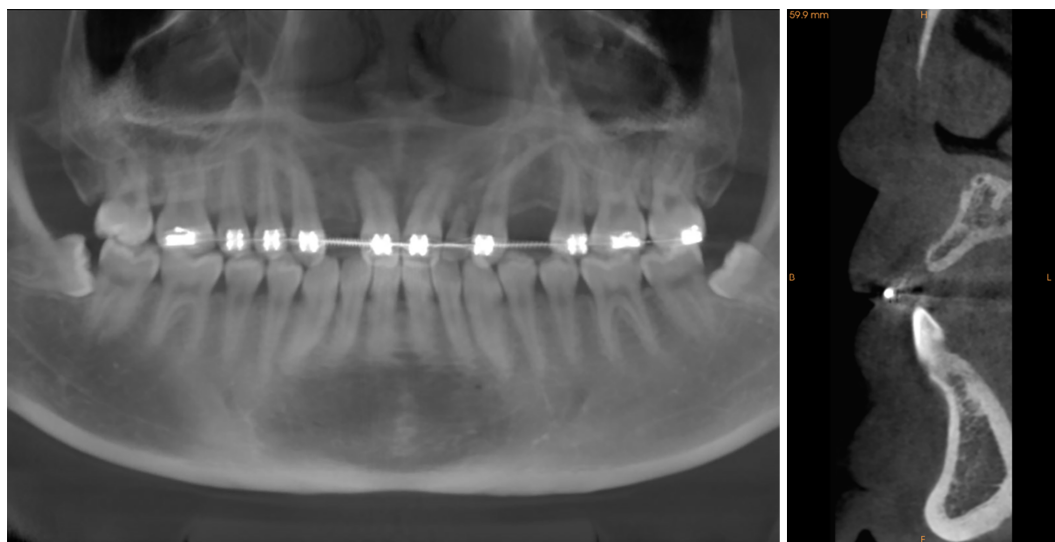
Cone-beam computed tomography revealed considerable alveolar bone loss.
